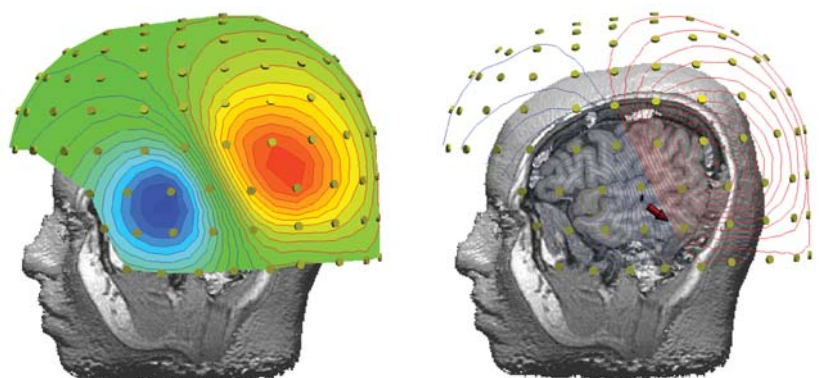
(Above left) Typical MEG suite showing dewar containing liquid helium and 275 recording sensors. (Above right) Recording from the first 37 MEG channels showing interictal epileptiform discharge (blue line) in a patient with focal epilepsy. (Below) Source localisation is then performed and overlaid on MR images for anatomical characterisation (red arrow).
